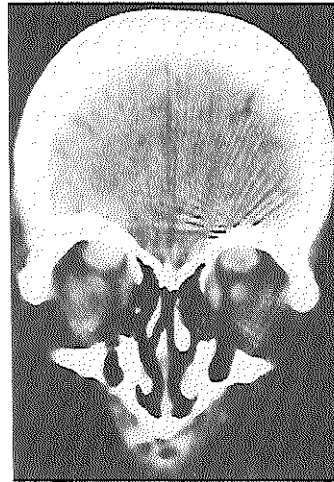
Coronal CT-scan of patient B after one month of corticosteroid treatment, showing a moderate decrease in the dimensions of the superior complexes.
